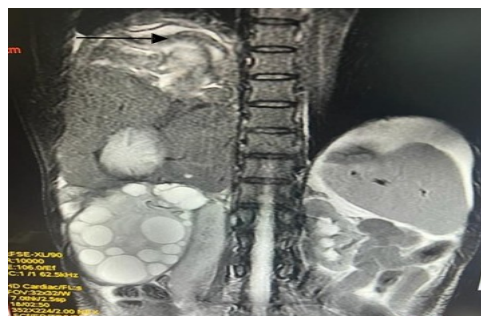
Showing MRI T2 coronal section with liver cyst with detached membranes.
